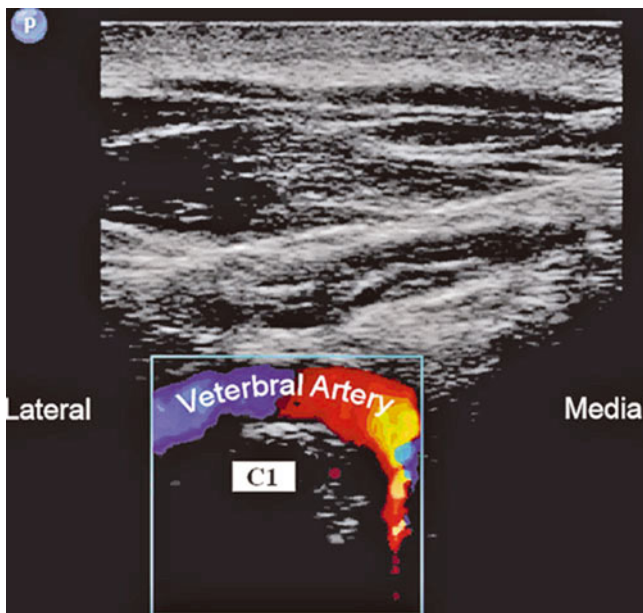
Atlanto-occipital joint (AOJ) injection. Sonogram showing the vertebral artery as it curves medially posterior to C1 (Reproduced with permission from Ohio Pain and Headache Institute)
